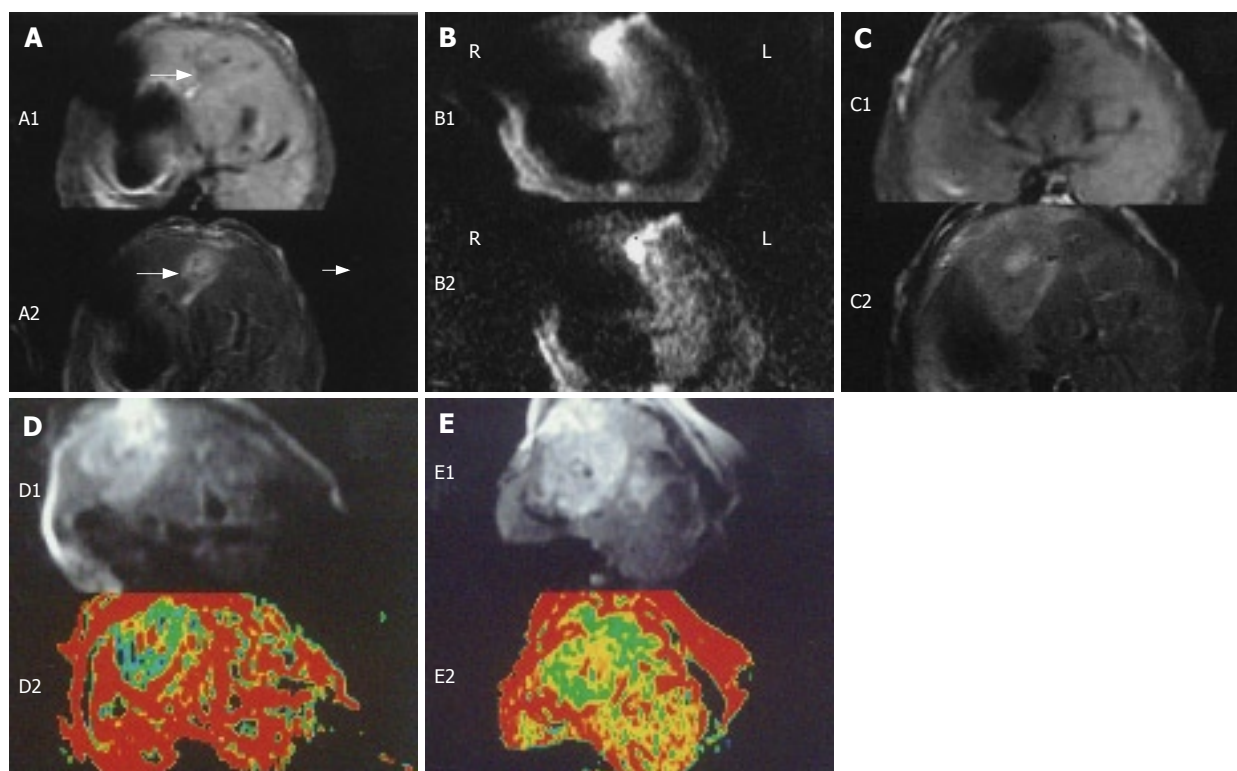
Image manifestations of hepatic VX-2 tumor on DWI, ADC map, T1WI or T2WI. A: A1, a low signal and obscure margin of VX-2 tumor on T1WI and A2, a slightly high signal on T2WI on the 7th day after implantation; B: a high signal and distinct margin of VX-2 tumor on DWI when b value was 100 (B1) or 300 (B2) s/mm^2 and low SNR when b value was 300 (B2) s/mm^2 on the 7th day after implantation; C: C1, a low signal of VX-2 tumor on T1WI and C2, a slightly high signal of it on T2WI and a lamellar high signal in the tumor center on T2WI on the 14th day after implantation; D: A high signal and distinct margin of VX-2 tumor on DWI when b value was 100 s/mm^2 (D1) and low signal of VX-2 tumor and a lamellar high signal in its center on the map of ADC on the 14th d after implantation (D2); E: A high and uneven signal of VX-2 tumor on DWI when b value was 100 s/mm^2 (E1) and low signal of VX-2 tumor while a high signal in the center tumor on the map of ADC on the 21th d after implantation (E2).
